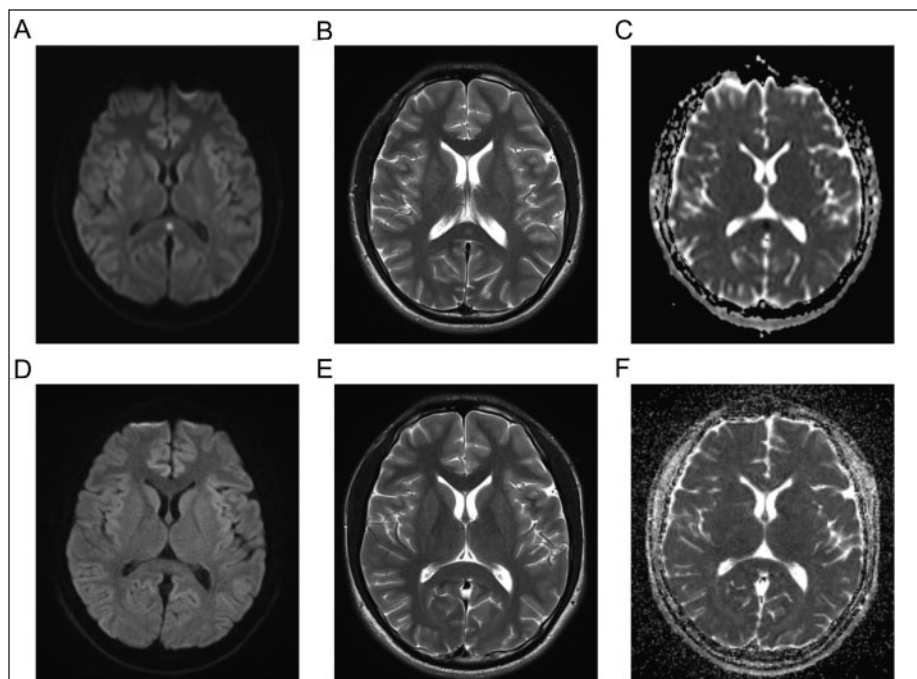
(A) Diffusion-weighted and (B) T2-weighted magnetic resonance images demonstrate a high intensity signal in the splenium of the corpus callosum, and (C) an apparent diffusion coefficient map image shows reduced diffusion in the aforementioned area. Three months later, all the lesions are completely resolved (D-F).
